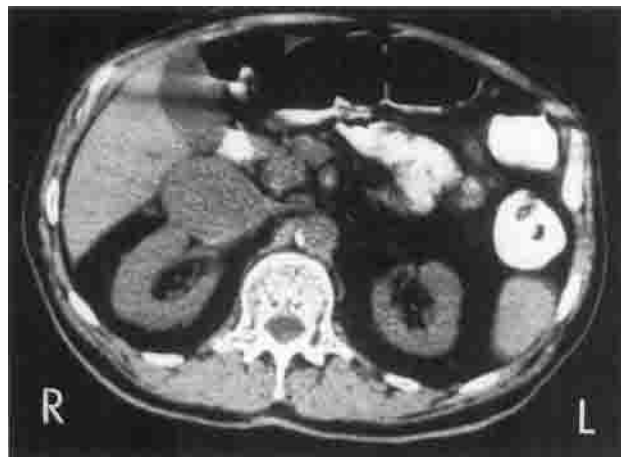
Case 1: Computed tomography of the abdomen showing a 5 cm well-circumscribed mass contiguous with the right renal vein.
